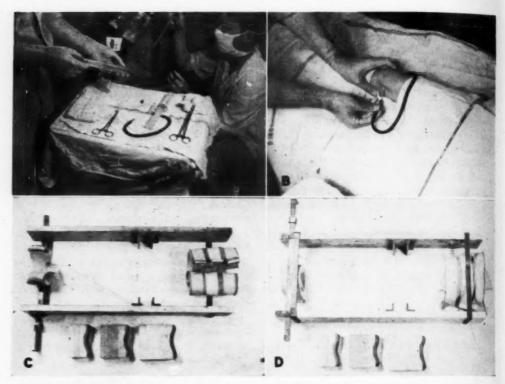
Steps in the technic of oxygen injection and radiography. A. The adapter for loading the syringe with oxygen is handed to the assistant for connection with the oxygen tank. B. The skin is prepared as for any surgical procedure and the knee is draped. The patella is pushed laterally as the needle is inserted near its superior articular margin. C and D. Knee-spreading device viewed from above (C) and below (D).
